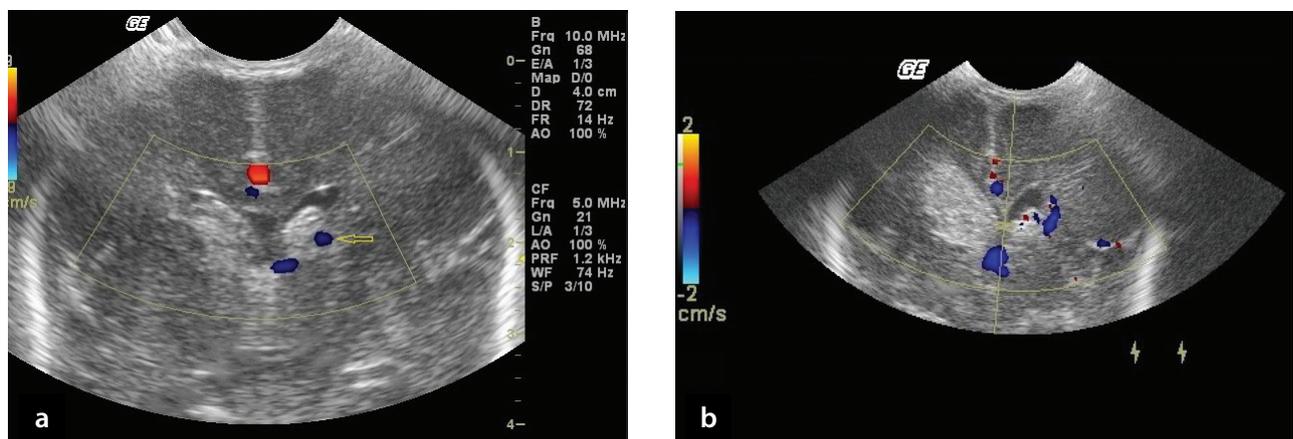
Neonate 27 GWs with bilateral IVH Grade II: a. Colour Doppler image showing left TV (arrow). Right TV was not depicted. Thrombi within lateral and 3rd ventricles. b. Two days later. Right PHI has occurred and left IVH Gr II remains. Right TV was again not demonstrated with colour Doppler. The left IVH Grade II progressed later to Grade III with patent, though displaced left TV (not shown).
